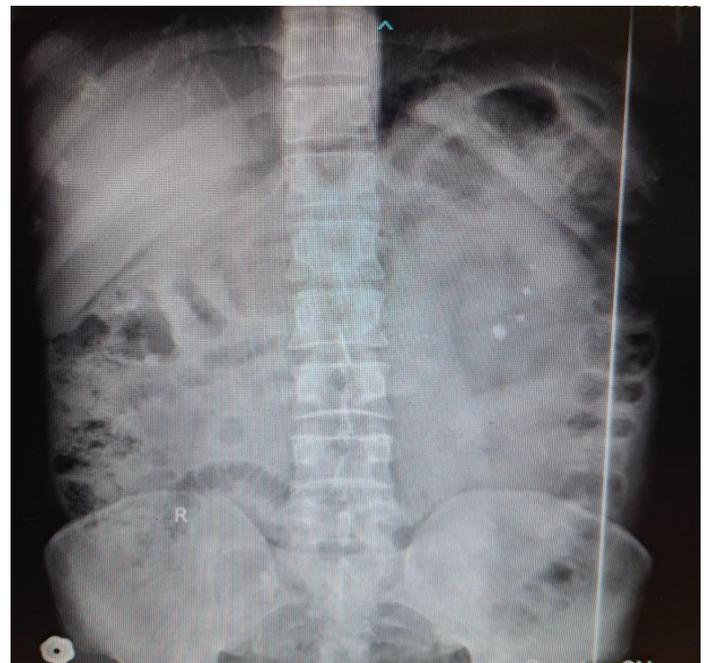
xray kub image showing stones in both kidneys and right upper ureter
